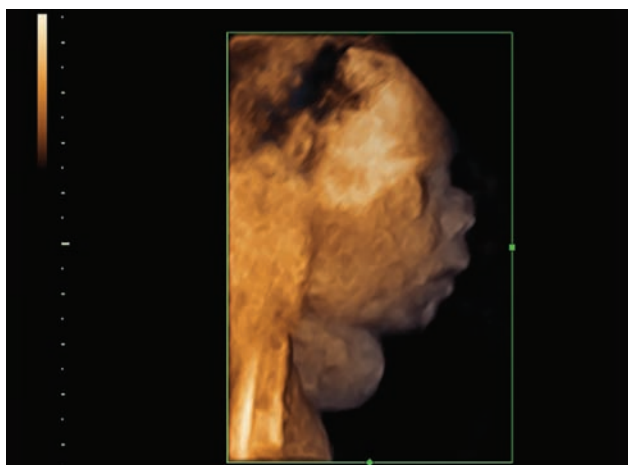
Three-dimensional ultrasound fetal profile in which the previous cervical tumor is observed
